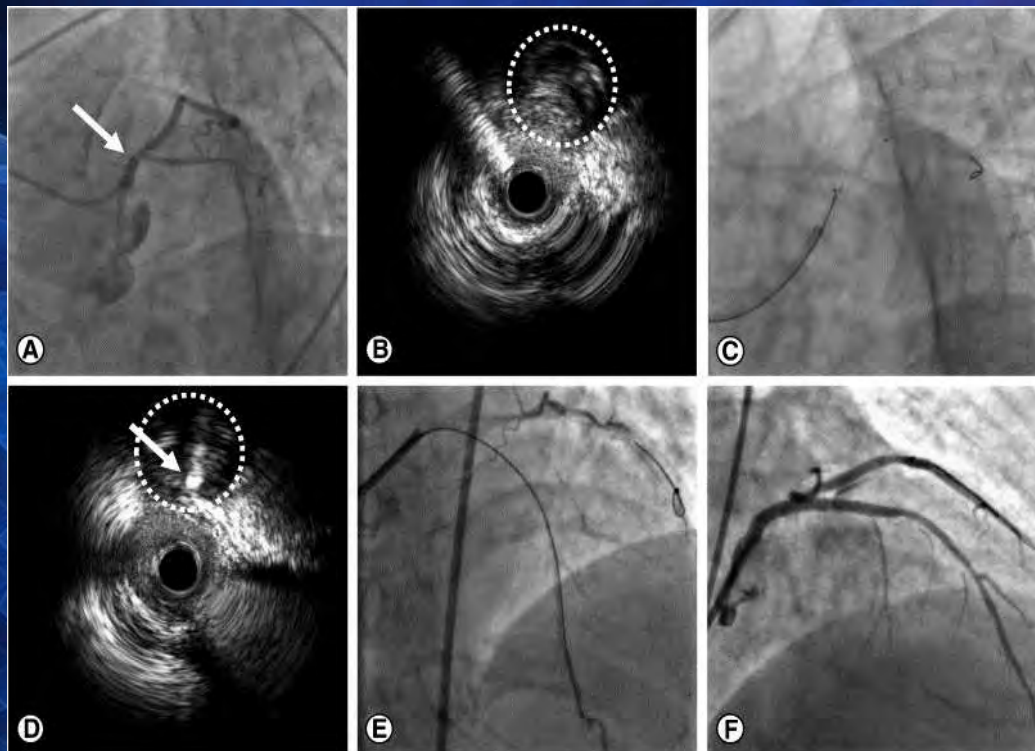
Steps of intravascular ultrasound-guided wiring technique. A: Chronically occluded left anterior descending artery and a blunt stump with a side branch. B: A soft-tip guidewire (Runthrough®, Terumo, Aichi, Japan) was placed in the adjacent side bran...
